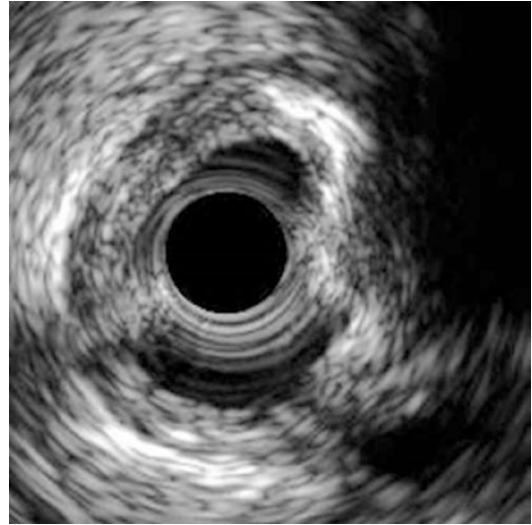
Typical intravascular ultrasound findings of calcified nodule. (1) A convex shape of the luminal surface; (2) a convex shape of the luminal side of calcium; (3) an irregular luminal surface; and (4) an irregular leading edge of calcium
